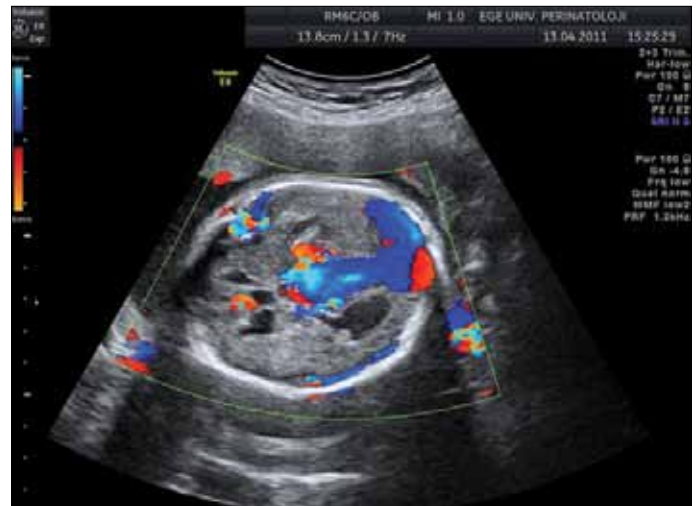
Turbulent blood flow in VGA through color Doppler mode
